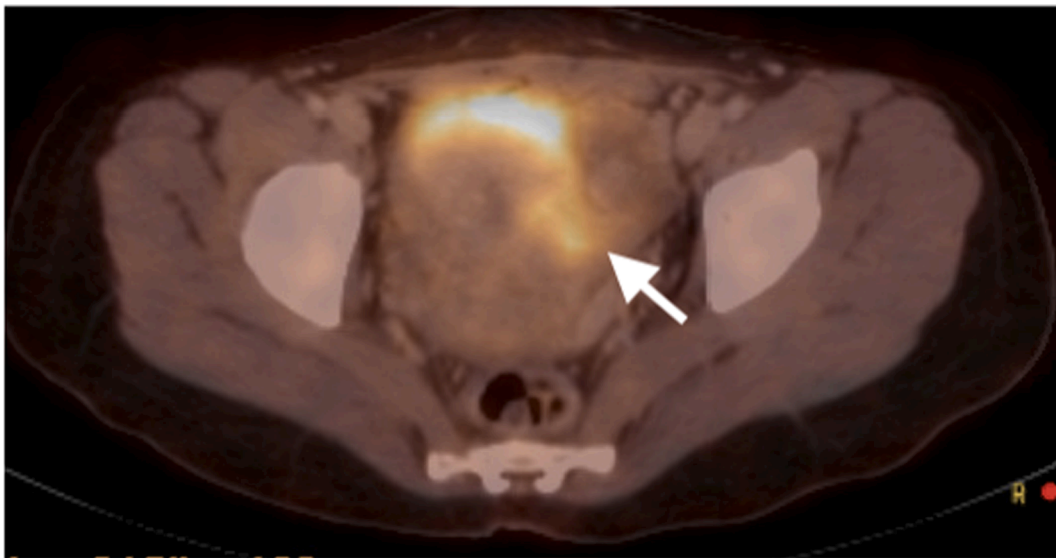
PET CT showed an ill defined 4.3 cm hypermetabolic, hypoattenuating mass in the lower uterine segment.
